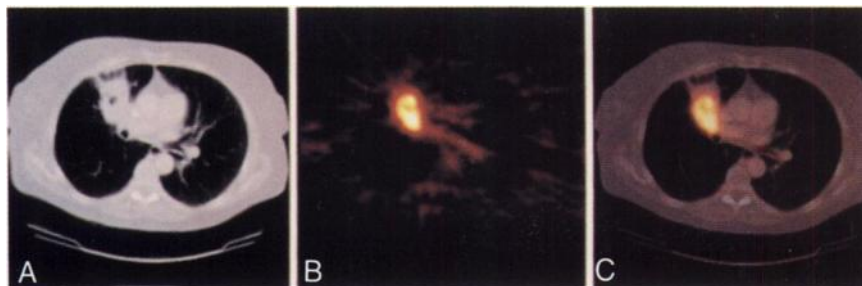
(A, B, C) CT, PET and merged images, respectively, from Patient 1.
